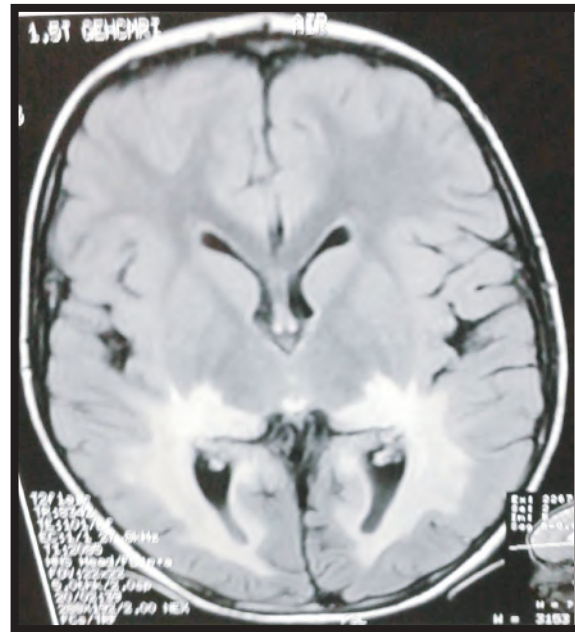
FLAIR image of brain MRI showing hyper intensity involving posterior periventricular white matter
